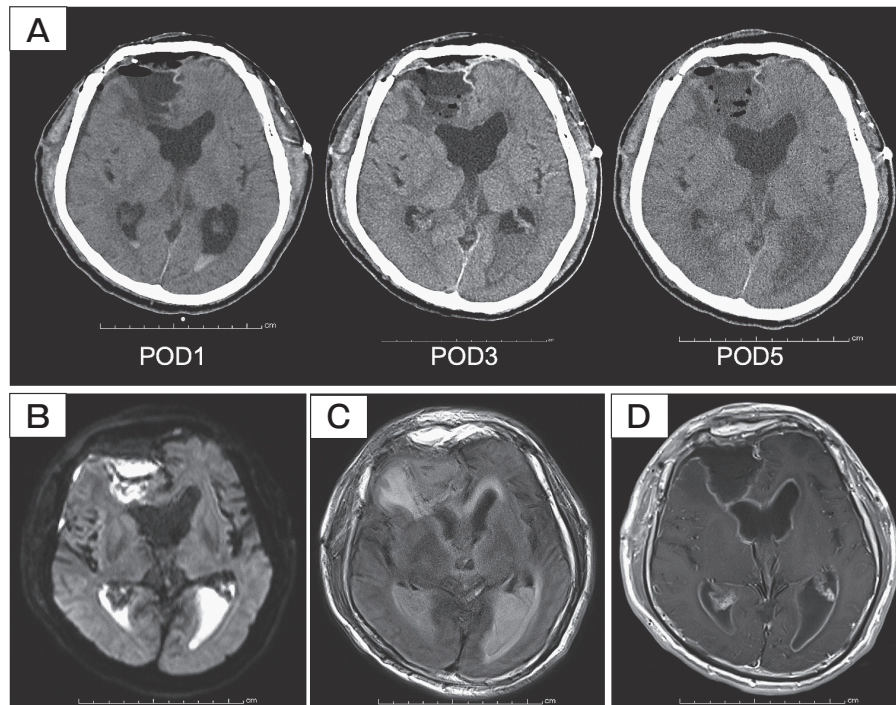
Radiological images after craniotomy. A, Sequential CT images after the craniotomy on POD 1, POD 3, and POD 5. Fluid in the bilateral posterior horns of the lateral ventricles increased sequentially. The resection cavity was filled with a fluid-like lesion on POD 5; B, A diffusion-weighted image on POD 5 shows hyperintensity of the fluid, implying the existence of an abscess; C, Fluid-attenuated inversion recovery MRI shows brain edema surrounding the resection cavity and subventricular zone; D, Gadolinium-enhanced T1-weighted MRI. The resection cavity rim and ventricular wall are enhanced. POD, postoperative day; CT, computed tomography; MRI, magnetic resonance imaging.
